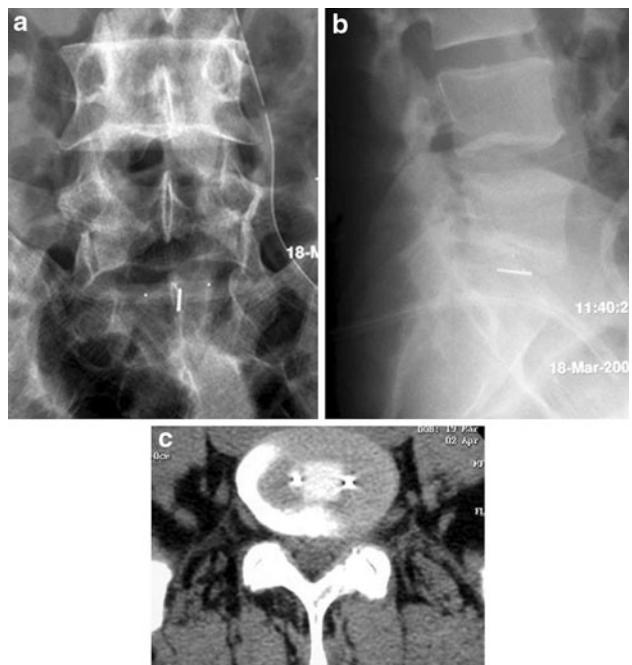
Plain radiographs on anteroposterior (a) and lateral (b) view show correct positioning of NUBAC prosthesis at L5-S1 level. CT scan (c) in axial view show the desired positioning of the implant inside the disc
